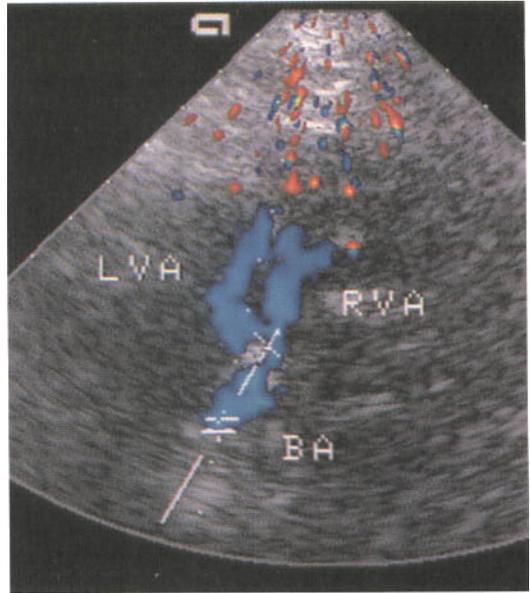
'Y'-sign. Color Doppler flow image of the vertebral confluence and the proximal basilar artery. (Image courtesy of Dr Eva Bartels.)
